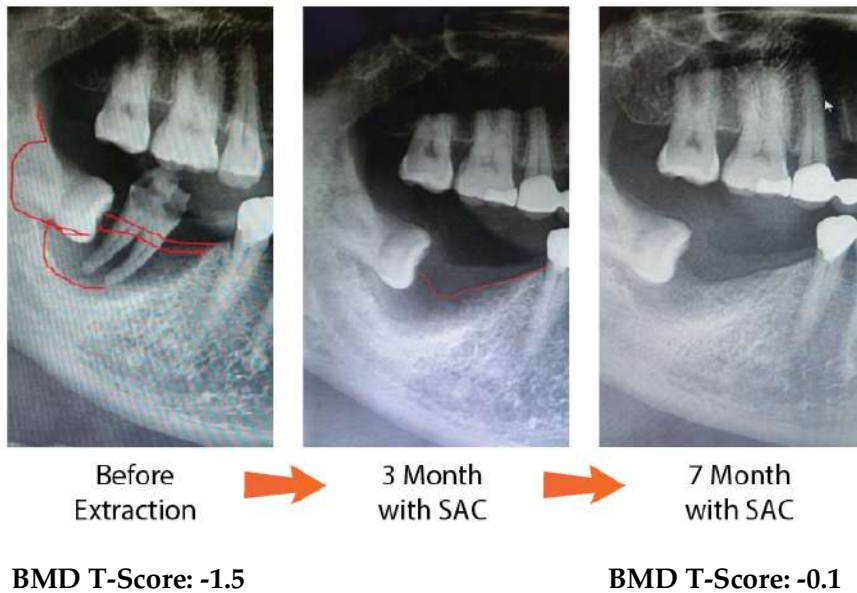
The X-Ray Image for an Asian Male Who is 58 Years Old, Conducted Molar Tooth Extraction; The Dental Bone Growth After Treating AIC for 7 Months without any Cotreatment.
